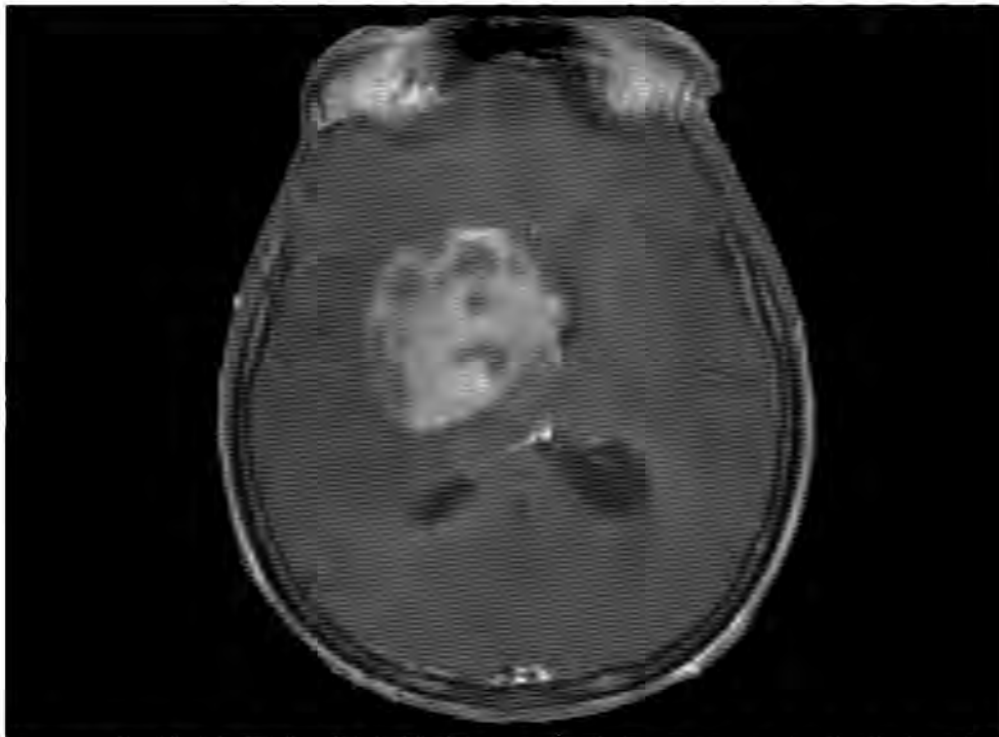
Axial MRI shows a heterogeneously-enhancing right periventricular mass.
